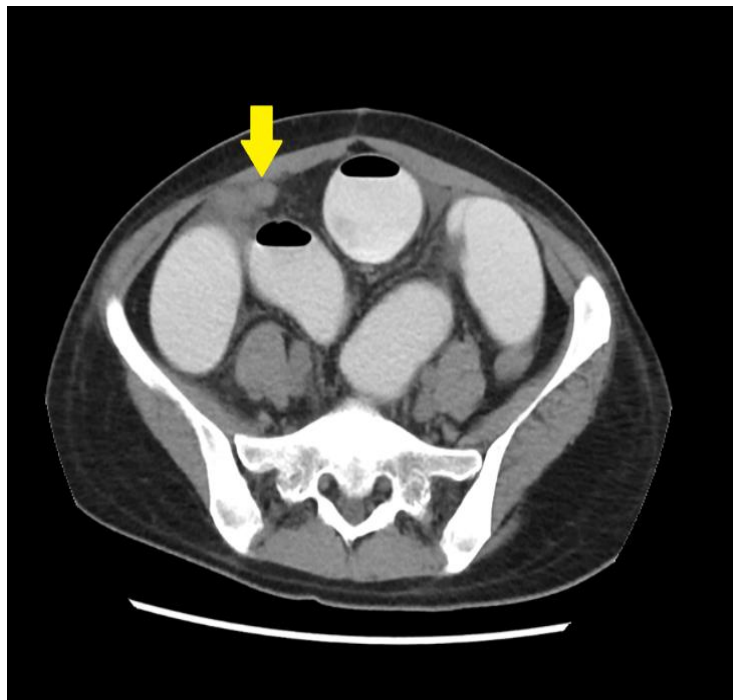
Axial contrast-enhanced CT image of the lower abdomen shows dilated loops of contrast-filled small bowel, consistent with small bowel obstruction. A blind-ending tubular structure tethered toward the terminal ileum (yellow arrow) is visualized, representing a Meckel’s diverticulum, which appears to be the lead point causing obstruction.
